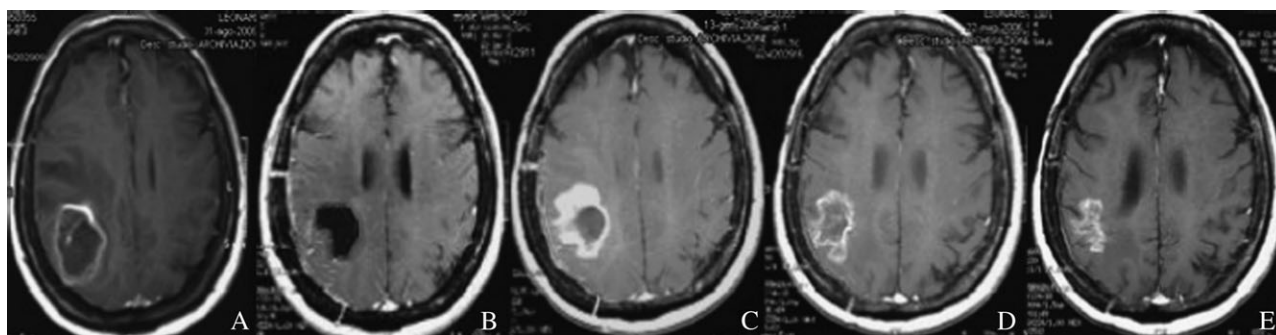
Clinical course of pseudoprogression in a 65-year-old patient with glioblastoma. (A) Presurgical MRI scan. (B) Postsurgical MRI scan. (C) MRI scan performed 1 month after combined TMZ/RT; adjuvant TMZ was continued. (D) Four months later, during administration of maintenance TMZ. (E) Eight months later, during administration of maintenance. Reproduced with permission [48].
